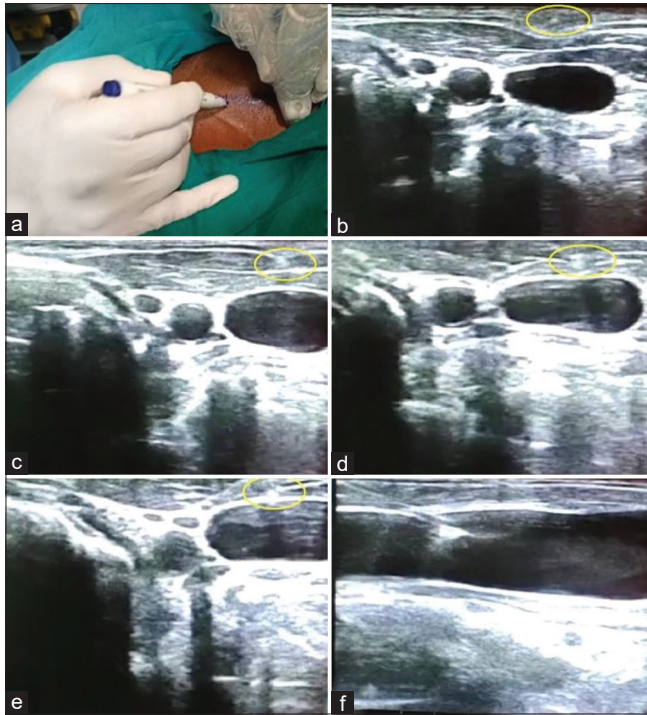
The scan-as-you-go (SAYGO) technique in a patient: (a) Pre-puncture marking. (b–f) serial ultrasound images of the SAYGO technique. The yellow circle denotes the hyperechoic tip of the needle
